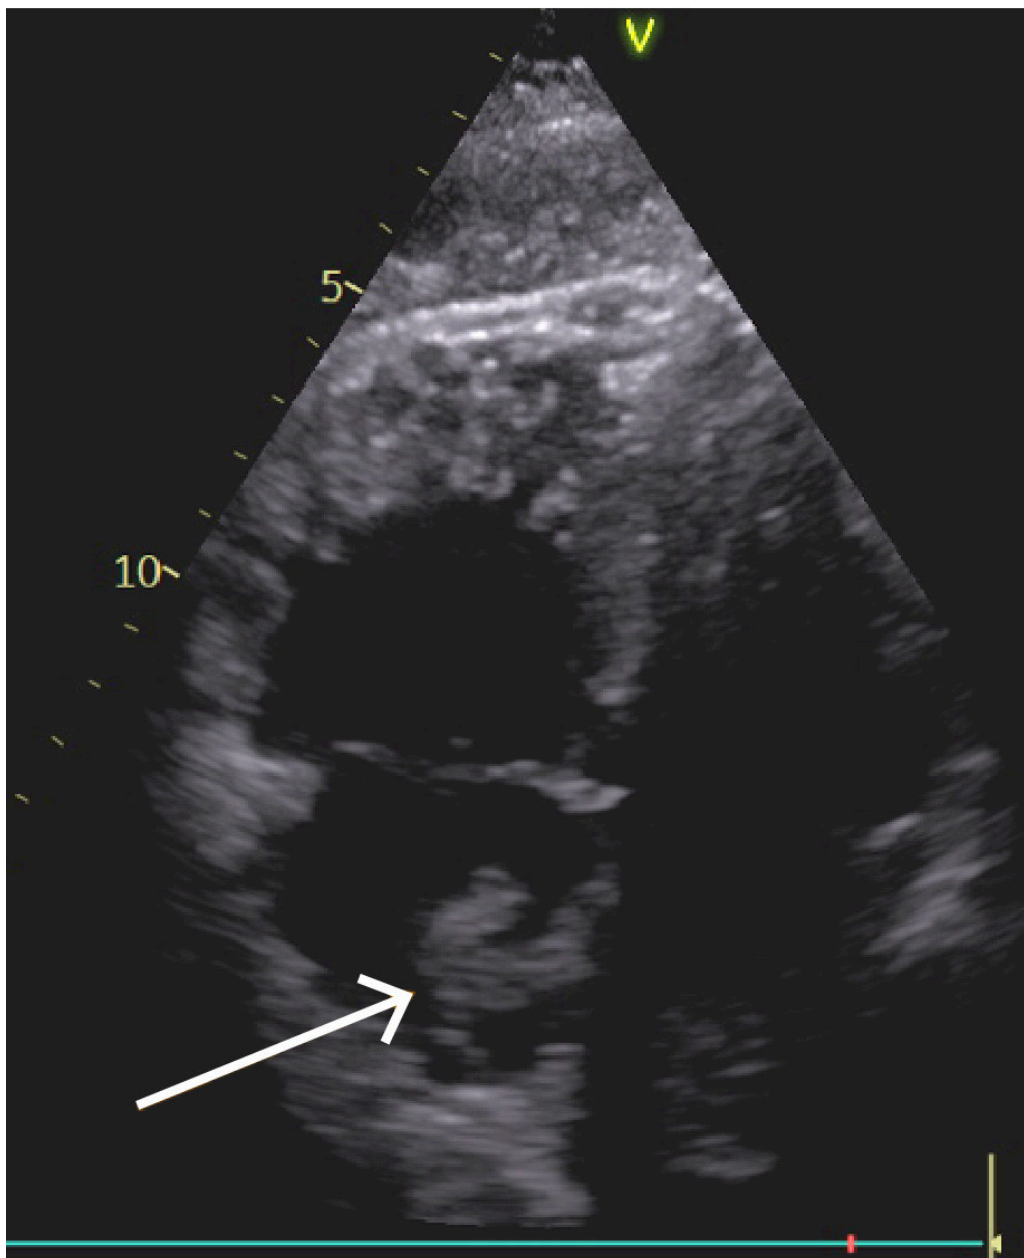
Echocardiography. Right ventricle, upper left; right atrium, lower left. Flapping mass in right atrium (arrow), raising suspicion of thrombosis – so-called ‘clot in transit’.
